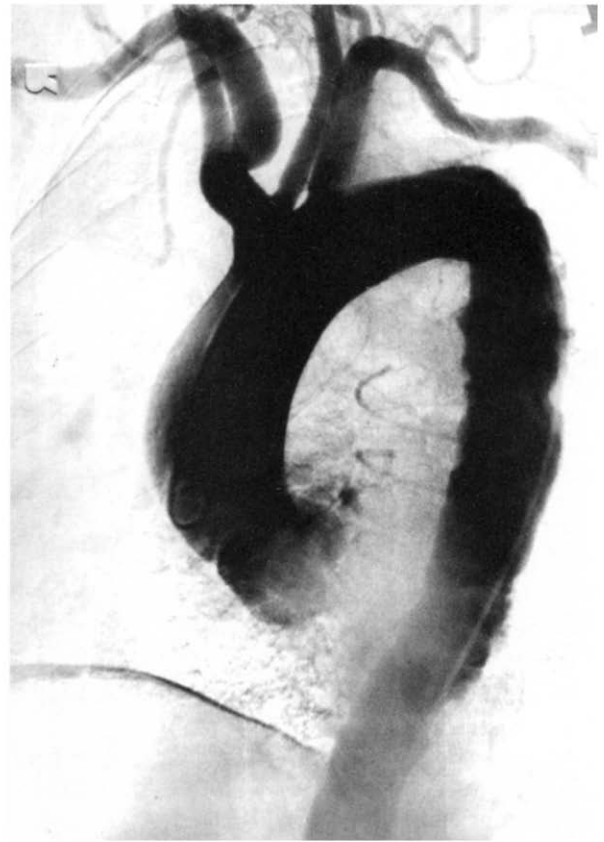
Aortic angiogram confirms diffuse atherosclerotic disease in patient 3 (Table II). This patient had a penetrating ulcer confirmed by means of CT scan.
